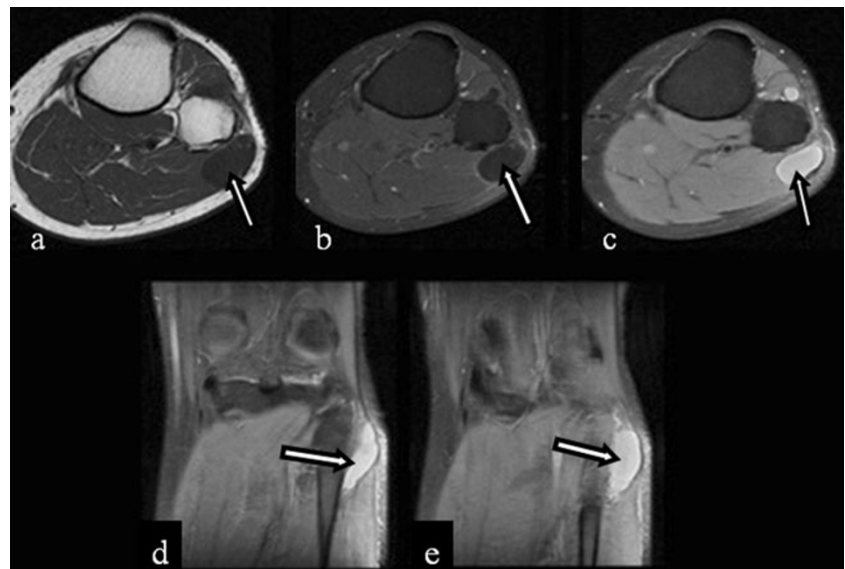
Common peroneal nerve sheath ganglion cyst. The axial (a) T1-weighted, (b) contrast-enhanced fat saturated T1-weighted, (c) fat saturated proton density weighted images and two sequential coronal (d, e) fat saturated proton density weighted images show a cystic lesion (arrows) at the lateral aspect of the fibula head extending caudally
